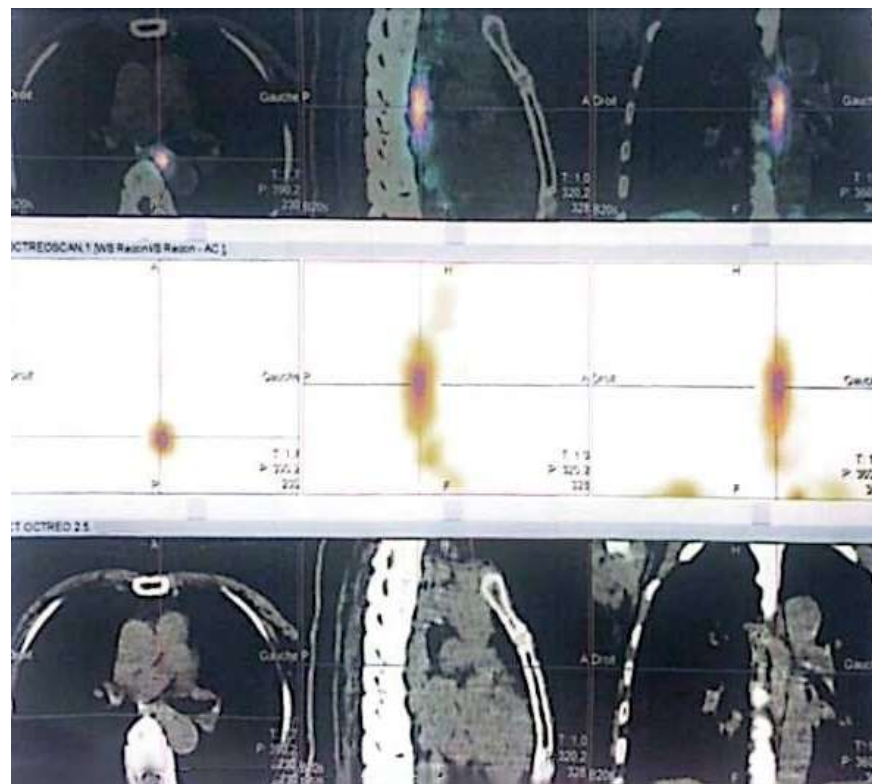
SPECT/CT image of a 99mTc-Tektrotyd® scintigraphy showing tissue formations in the middle third of the esophagus (representative case).
